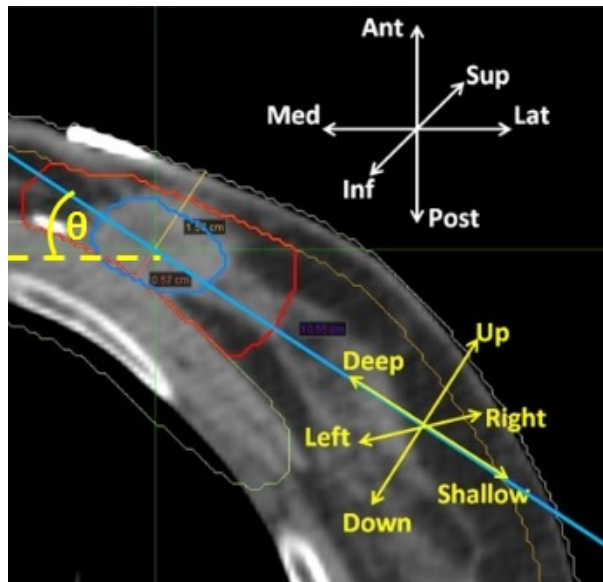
The standard CT coordinate system (white) and the rotated needle coordinate system (yellow) used to assess seed displacements.
